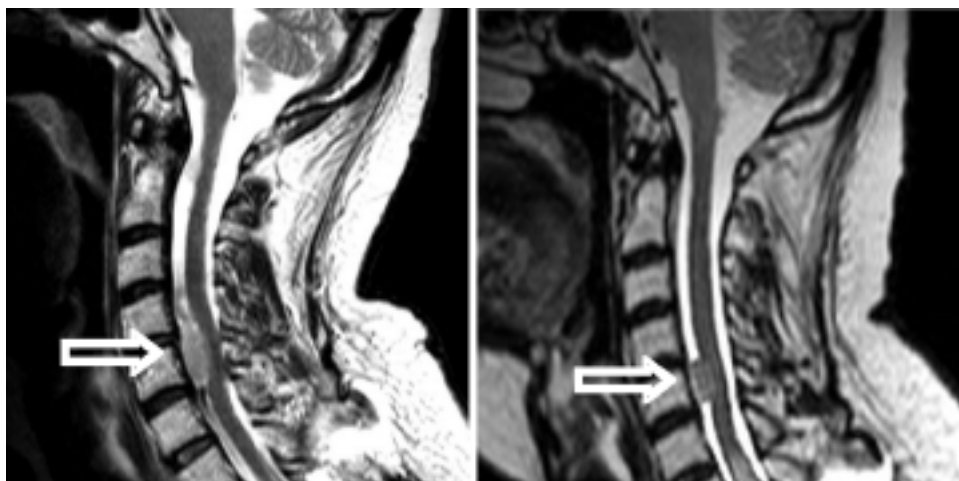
Left:* Sagittal T<sub>2</sub>-weighted MR image obtained in a patient undergoing surgery and conventional radiotherapy for a malignant peripheral nerve sheath tumor at the C-6 level (*arrow*). The recurrent tumor was compressing the spinal cord anteriorly. Instead of repeated surgery, CyberKnife radiosurgery was performed using fiducial-free tracking. *Right:* Sagittal image acquired after spinal radiosurgery. The tumor has shrunk significantly (*arrow*) and the anterior cord compression has been eliminated.
